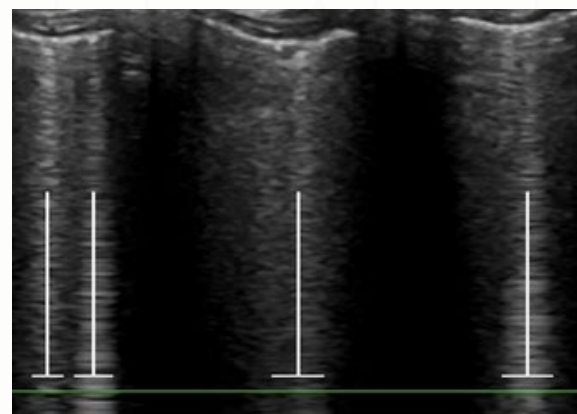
Ultrasound image of irregularly spaced B-lines in lateral view, suggesting early pneumonia.
